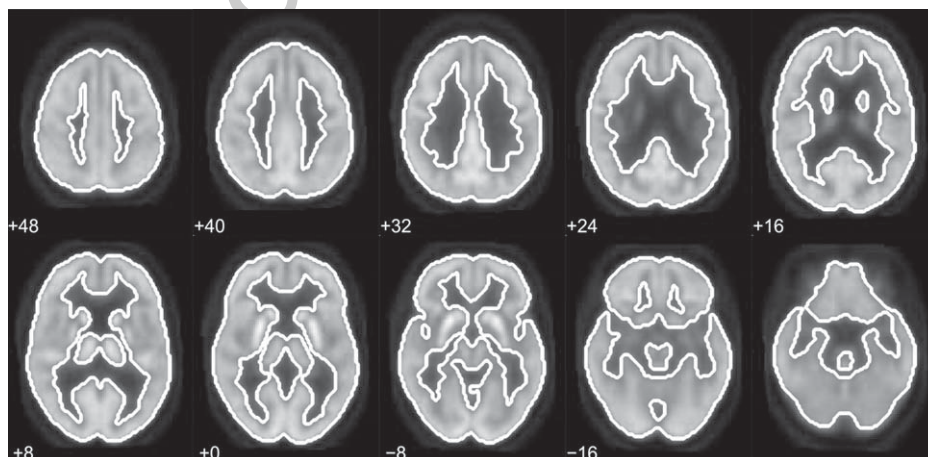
Parenchyma mask overlaid to the FDG template.
